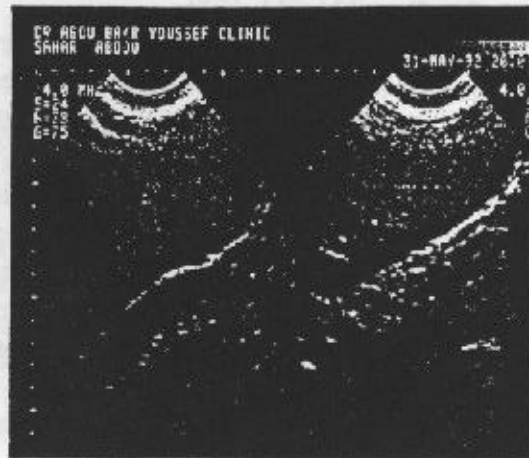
(b) Fatty B-mode ultrasound image
